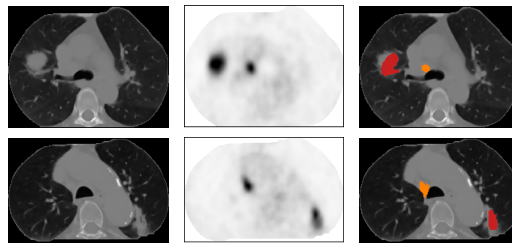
Examples of primary lung tumors and involved lymph nodes.<sup>4</sup> Each row shows one example, using a transaxial slice view for easier visualization. The left column shows the CT slices, the middle column the PET slices, and the right column shows the lung tumors (red) and involved lymph nodes (orange).
